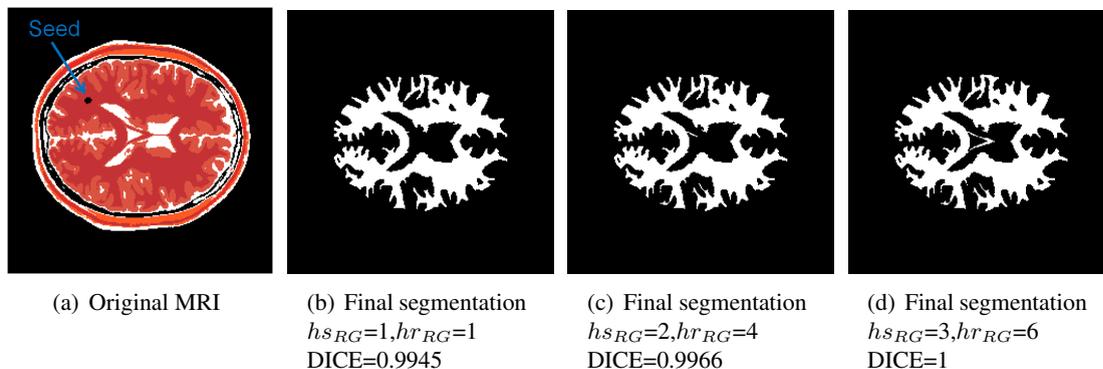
White matter segmentation of original labeled MRI image by using only RG.
